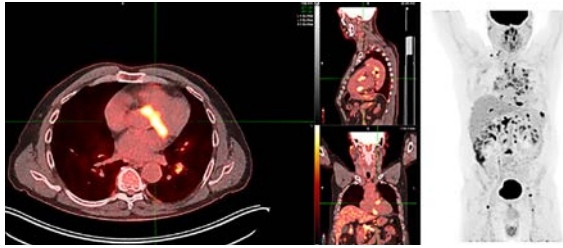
Focal intense fluorodeoxyglucose uptake in the basal anteroseptal and inferoseptal left ventricular myocardium and mediastinal lymph nodes (left). Overview of FDG uptake in lymph nodes in the neck, chest, upper abdominal, inguinal sites, lung, spleen and L3 vertebra (right).
